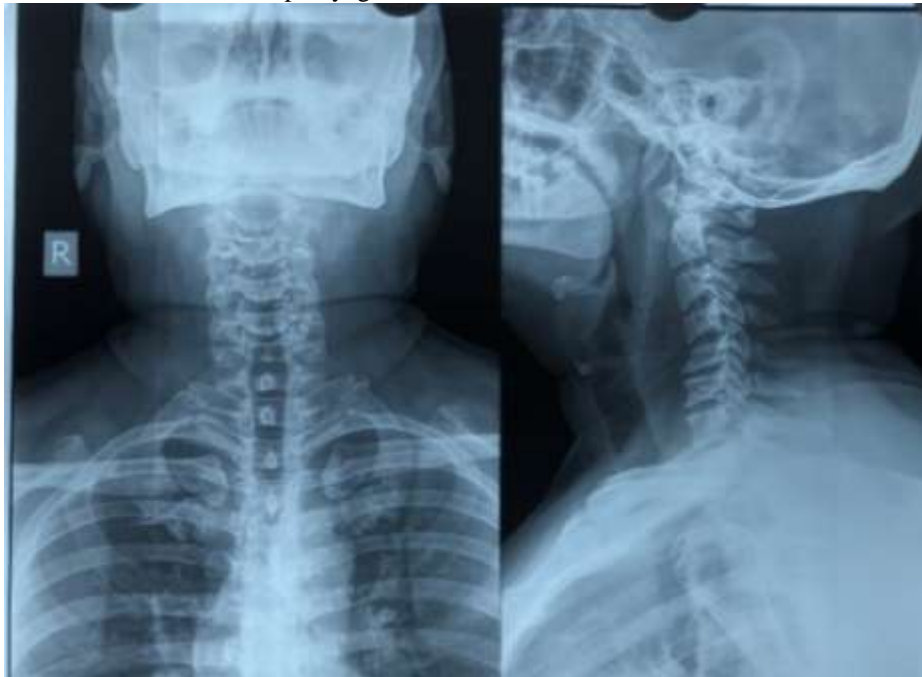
Anteroposterior & Lateral Neck Xray views.
